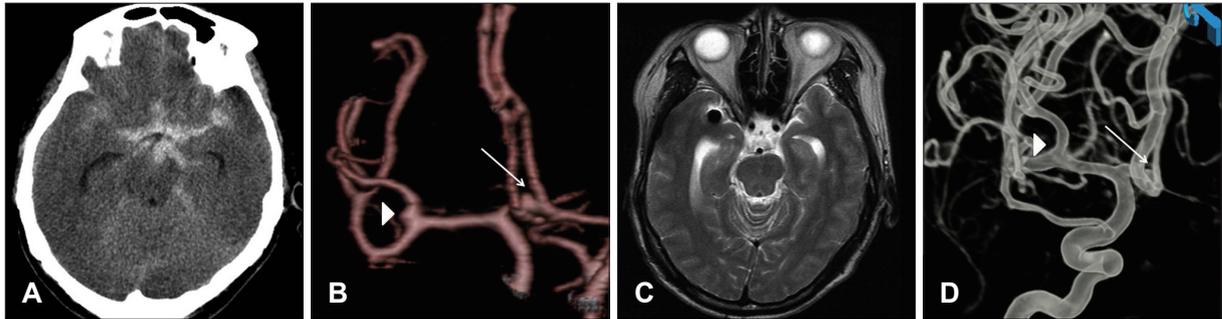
Radiological findings of case 1. A: Head computed tomography (CT) showing subarachnoid hemorrhage of Fisher's grade 3. B: Cerebral CT angiography. Arrows indicate anterior communicating artery and arrow head middle cerebral artery aneurysms, respectively. C: Brain magnetic resonance image demonstrating no definitive abnormal lesion in the brain stem. D: Postoperative cerebral angiography indicating complete disappearance of aneurysms and no vascular abnormality.
